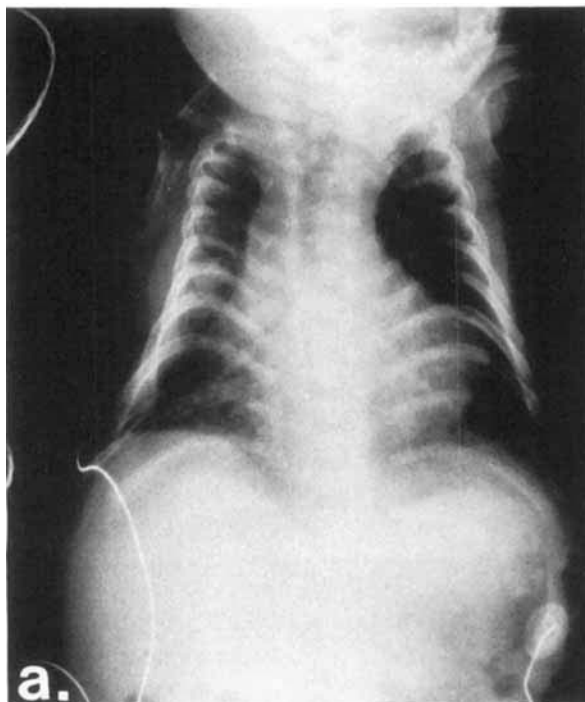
X-ray images of the propositus. a: A small thorax with upslanting ribs was visualized. b: Long fibulae and small proximal tibial epiphyses were found in images of the lower extremities.
